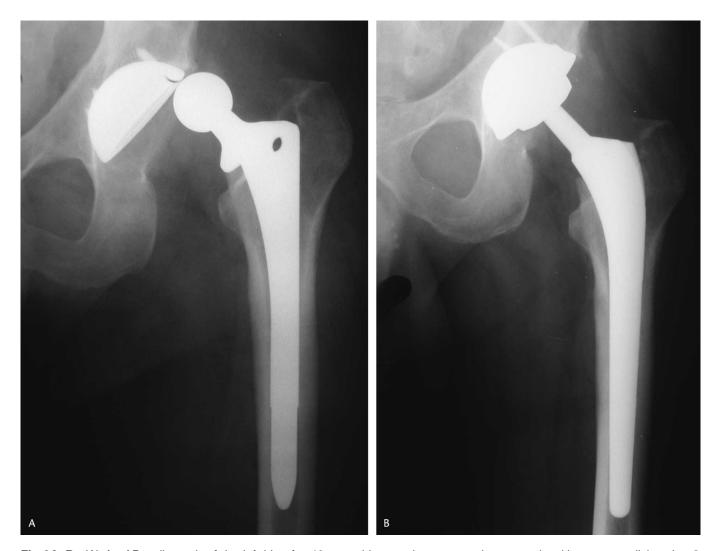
(A) An AP radiograph of the left hip of a 46-year-old man who presented emergently with recurrent dislocation 3 months after having uncemented primary THA at another institution is shown. (B) A radiograph of the same patient after treatment with revision THA done using the anterolateral approach using an Mallory-Head Porous offset femoral component and M²a-38 acetabular component shows satisfactory position and alignment. The patient has had no further dislocation.
